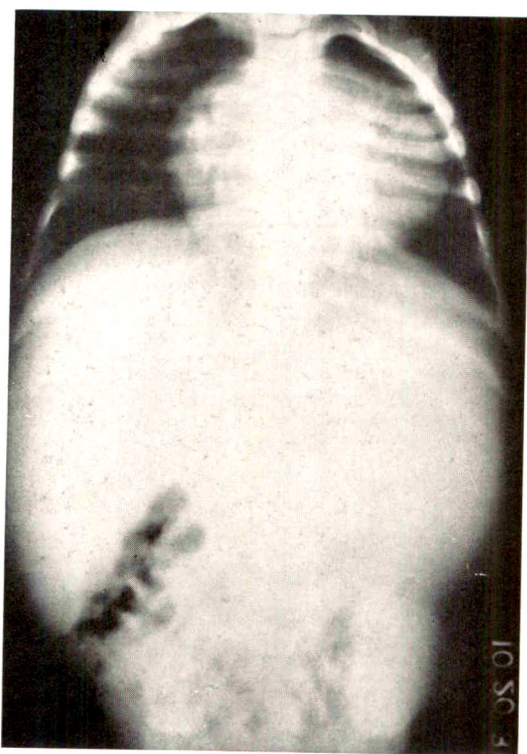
Case III. Diagnosis, erythroblastic anemia. Roentgenogram shows enlarged globular heart; accentuated trabeculation of ribs.
